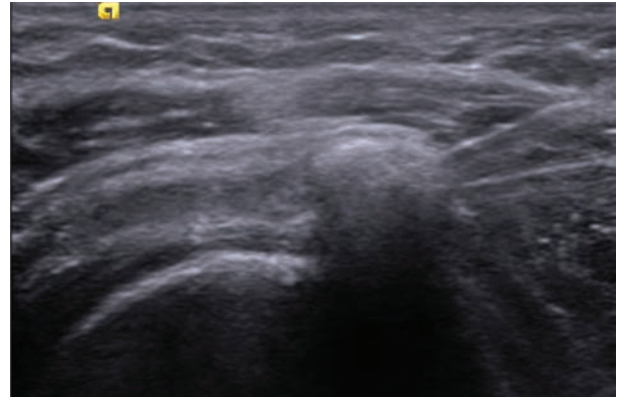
Ultrasound image of the double-needle technique. Both needles lay on the same coronal plane, with a correct angulation (25-30°) and both bevels facing each other
